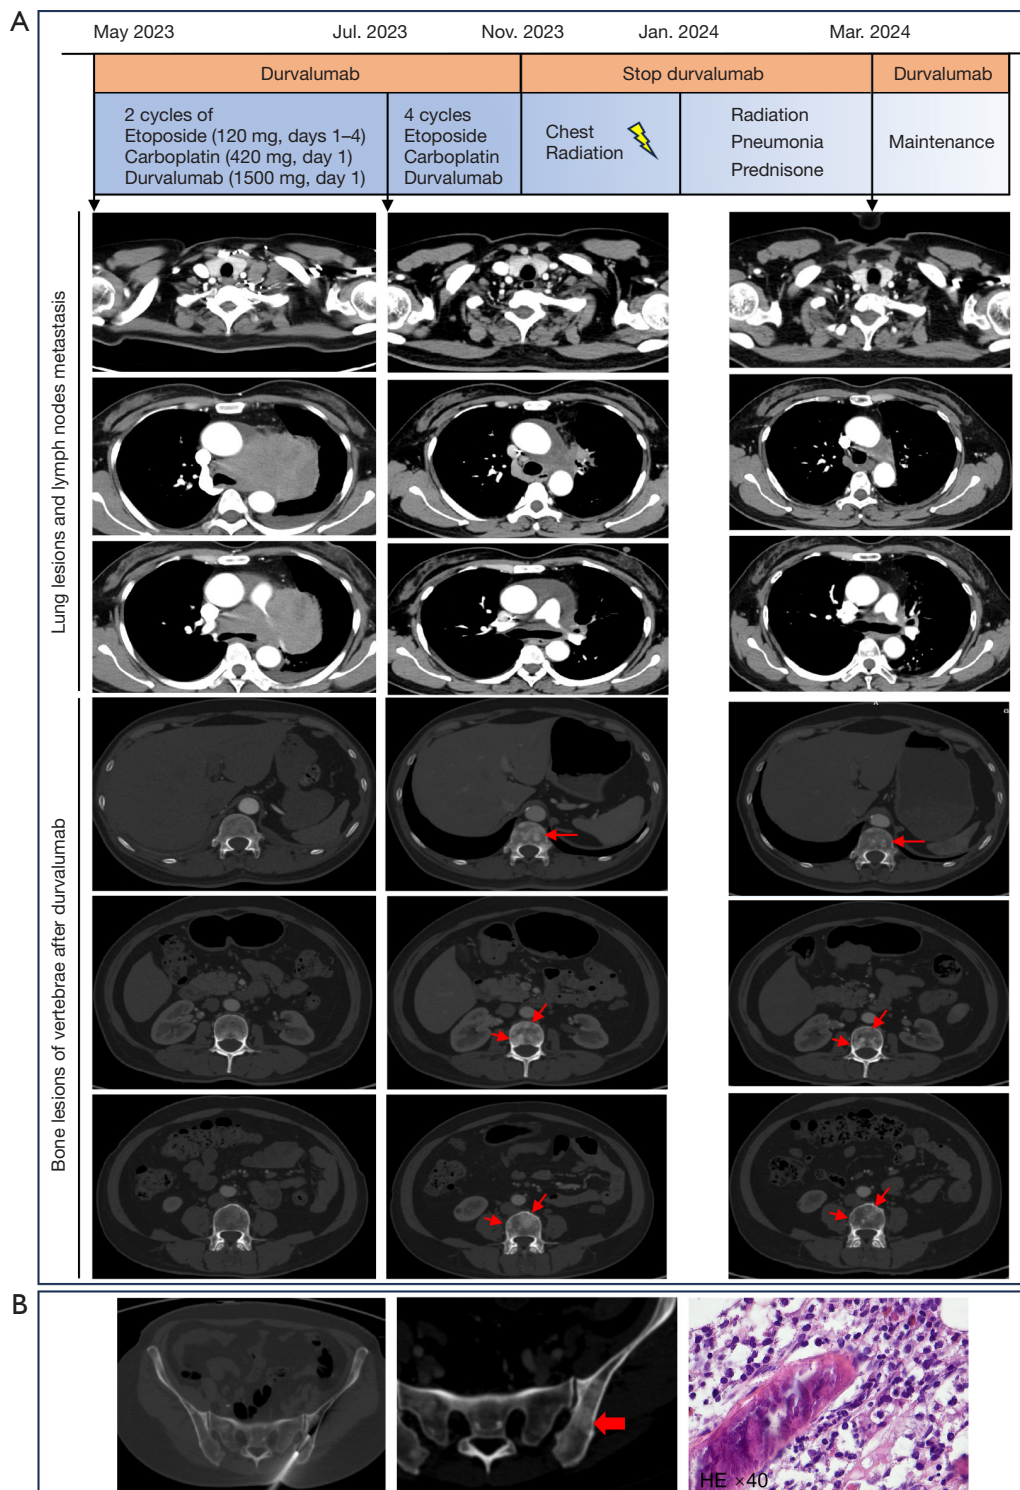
The timeline of the diagnosis and treatment of the patient. (A) The therapeutic management timeline and corresponding imaging. After 2 cycles of durvalumab treatment, the CT scan revealed multiple uneven increases in bone density in vertebrae (red arrow). Suspending durvalumab for 4 months and taking prednisone for 1 month, CT showed that the bone lesions were improving (red arrow). (B) The CT-guided biopsy was conducted in iliac bone, where there was an osteoblastic lesion (red arrow). Bone trabeculae were regularly arranged and normal bone marrow components were visible around them. No abnormal hematopoietic or tumor cells were observed. CT, computed tomography.
